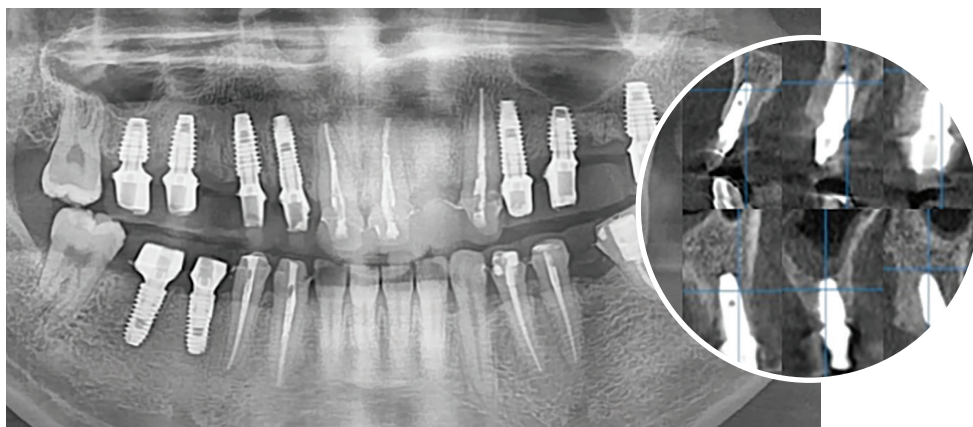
Post op panoramic X-ray view and CBCT shots, clockwise #7, #6, #4, #3, #12, #13, #15
